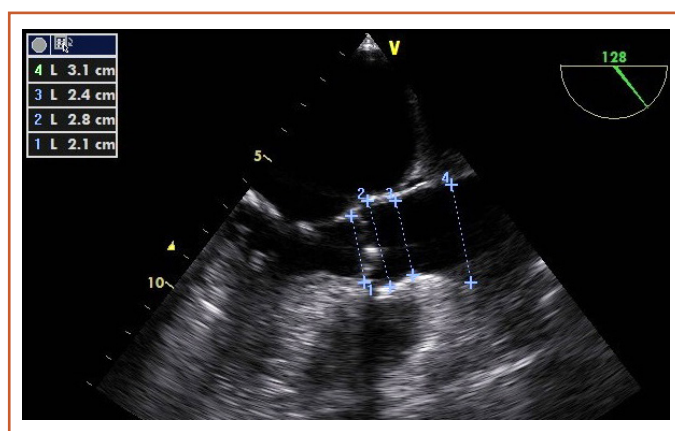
Measurements of midsystolic aortic annulus, sine valsalva, sinotubular product and resultant aortic diameters at transesophageal echocardiography longitudinal ax section.
